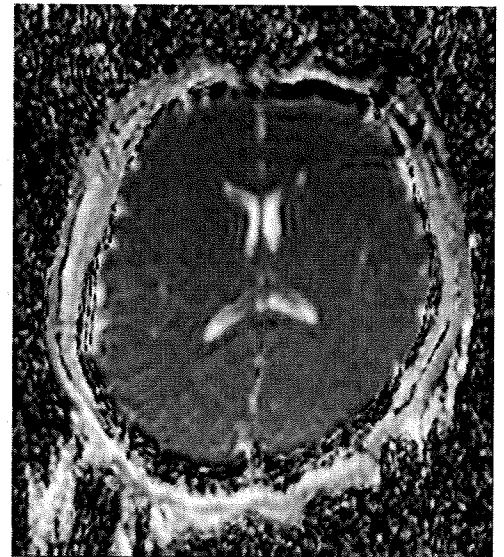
A 37-year-old woman. Apparent diffusion coefficient map of the brain obtained from postmortem MRI performed 36 h after confirmation of death shows low signal intensity across the entire brain parenchyma.
